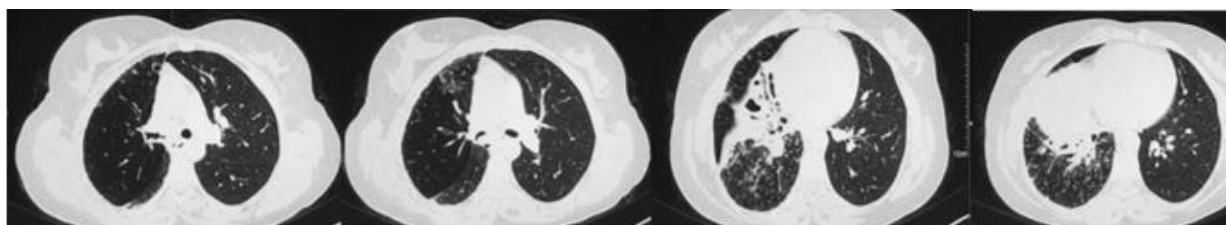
Lung CT show obstruction of the right primary bronchus, direct and indirect signs of atelectasis, bronchiectasis and bronchiolitis, ©
